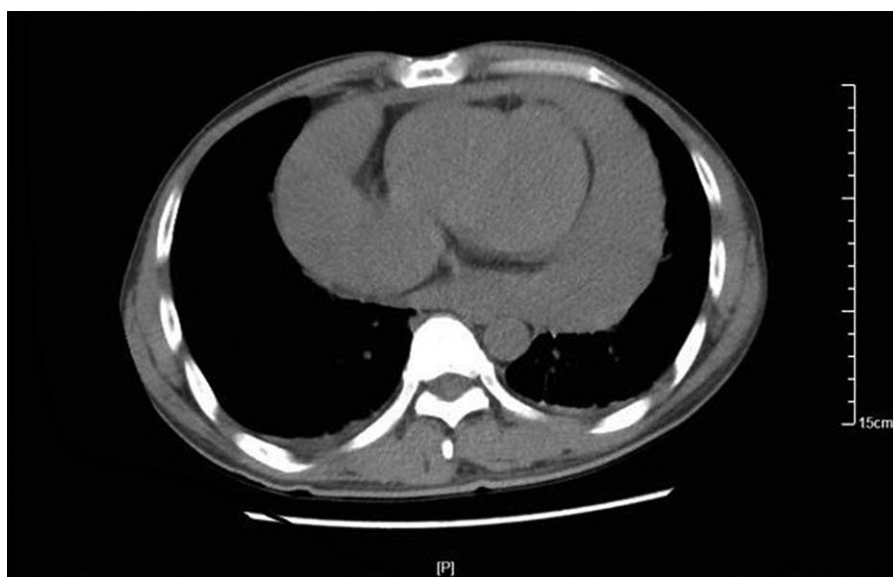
Chest CT showing pericardial effusion. CT=computed tomography.
